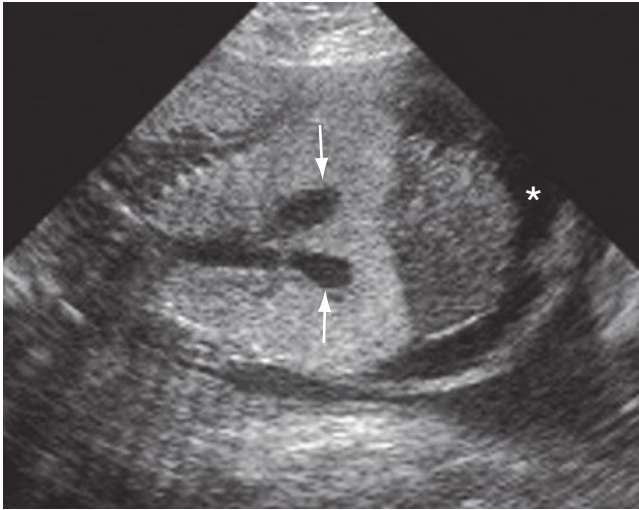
Sonogram of another fetus with laryngeal atresia and Fraser syndrome. Bilateral enlarged hyperechogenic lungs, fluid-filled bronchi (arrows), and ascites (asterisk) were present.
